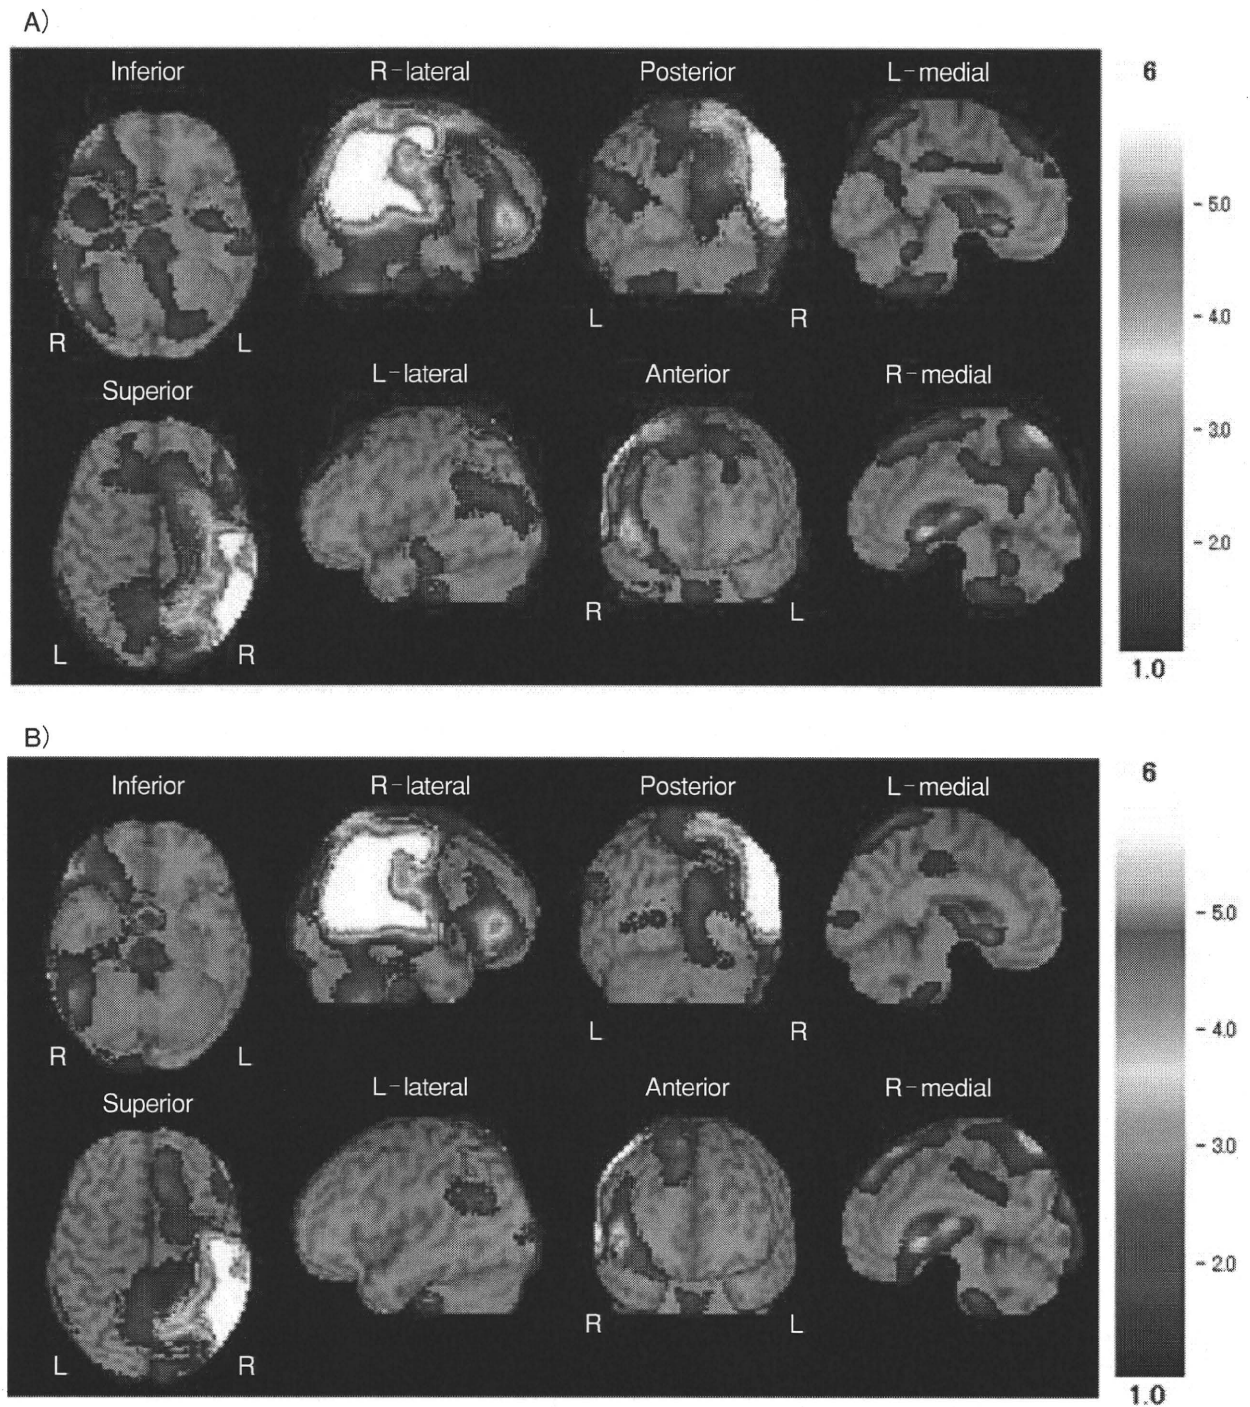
99mTc-ECD SPECT e-ZIS解析
